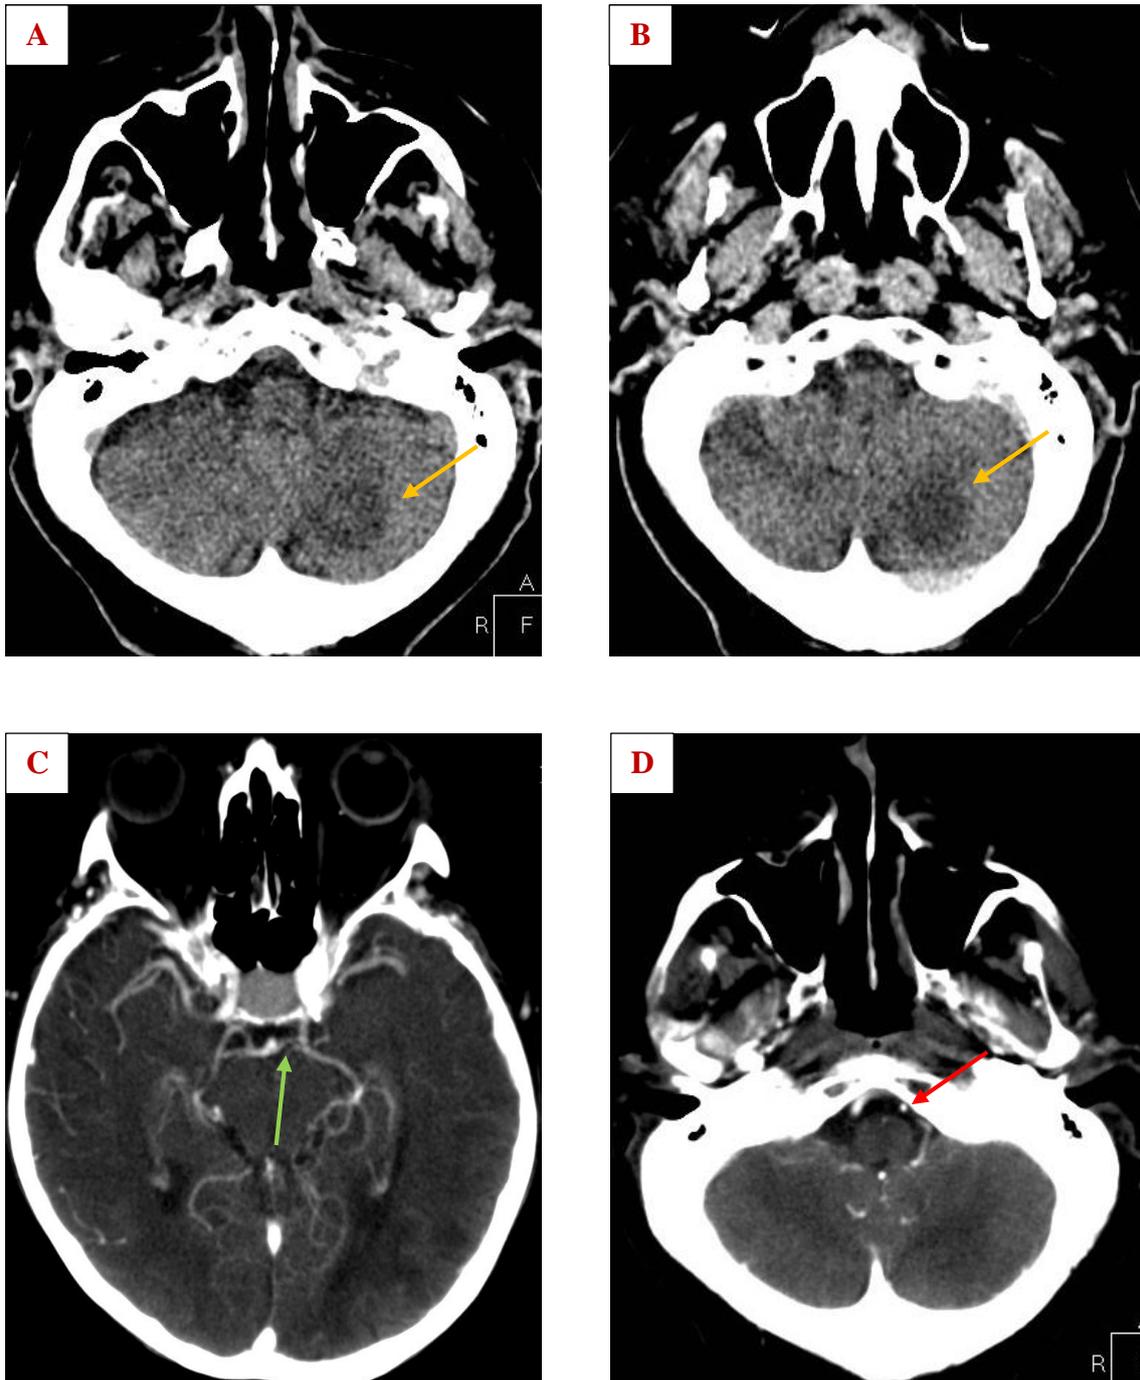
Unenhanced CT (A, B) shows subacute ischemic changes in the left cerebellar hemisphere (orange arrows) in a 71-year-old male patient. CT angiography (C, D) shows left PCA P1 hypoplasia (light green arrow) and left VA V4 segment hypoplasia (red arrow). CT: computed tomography, PCA: posterior cerebral artery, VA: vertebral artery. Image from Department of Radiology, Semmelweis University.
